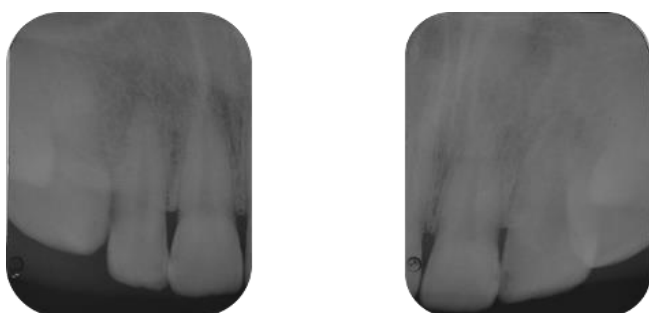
Intraoral periapical radiograph investigation. Note the level of the alveolar bone crest approximately 1–2 mm from the cemento enamel junction (CEJ).
